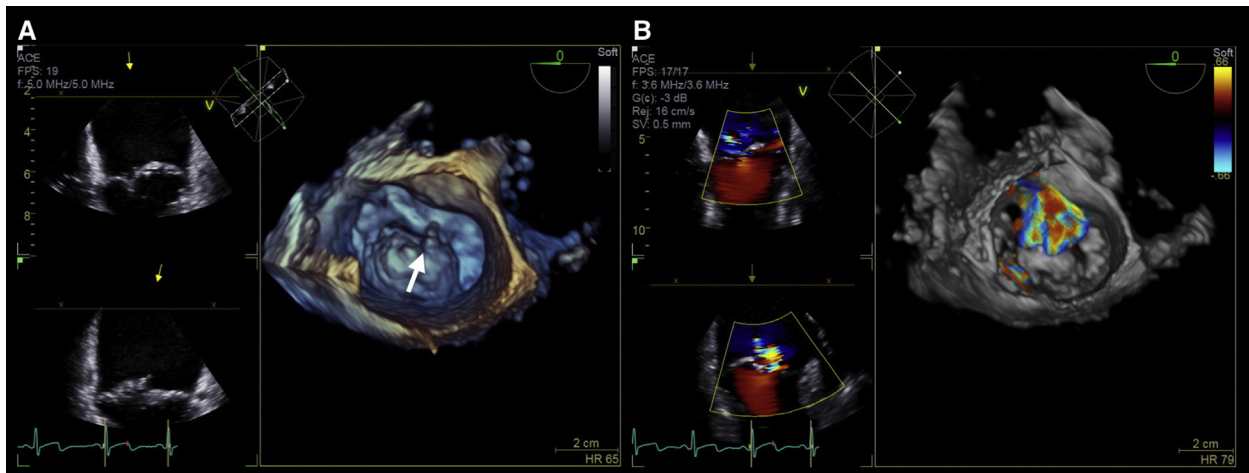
(A) Mitral valve seen en face in a 3D data set from the left atrial perspective (“surgeon’s view”). Flail large P2 segment can be seen (white arrow). (B) Mitral regurgitation jet seen with color flow Doppler, originating at the level of the flail P2 segment and directed anteriorly.
